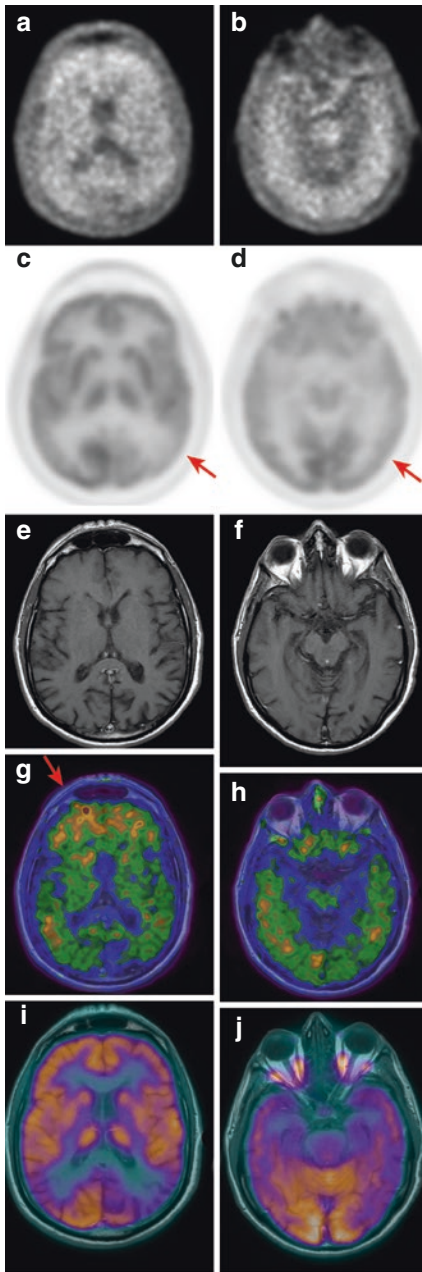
In (a) and (b) we report the axial views of a ^{18}F -florbetaben PET scan showing a pathological amyloid burden in brain in a 68-year-old male patient with clinical suspect of Alzheimer’s disease. In (c) and (d) we report the axial views of ^{18}F -FDG PET scan in the same subject showing a decrease of brain glucose consumption in the left parietal and temporal lobes (arrows). MRI scans are showed in (e) and (f) and PET/MR fusion imaging of ^{18}F -florbetaben and ^{18}F -FDG are showed in (g, h) and (i, j), respectively. The greatest amyloid burden in brain was detectable in frontal lobes bilaterally (g, arrow)
